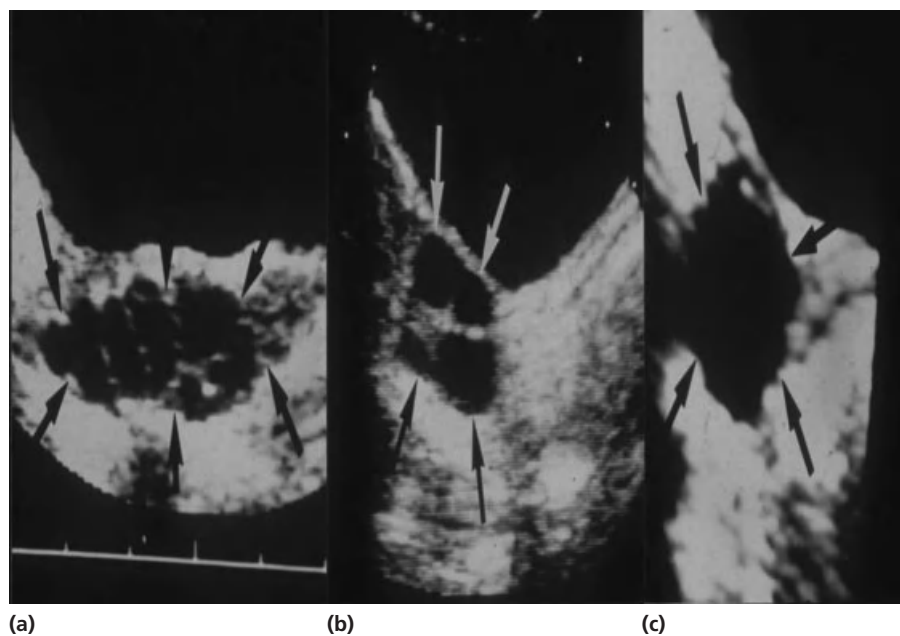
Pelvic ultrasound examinations of girls with (a) GDPP showing multicystic ovary characteristic of the effects of pulsatile gonadotrophin secretion, (b) the ovary in thelarche variant with several large cysts, and (c) the large single cyst present in McCune–Albright syndrome. Arrows outline ovarian structure. Marker bar depicts 1-cm intervals.
